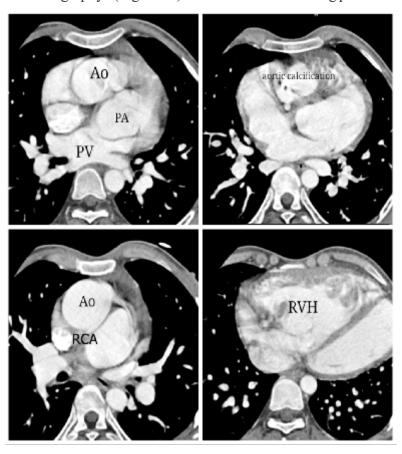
Preoperative cardiac CT showing Aorta (AO) anterior and to the right of Pulmonary Artery (PA), calcified aortic valve, Right Coronary Artery (RCA) arising from the non-coronary cusp at 6'o clock position and Right Ventricular Hypertrophy (RVH)
